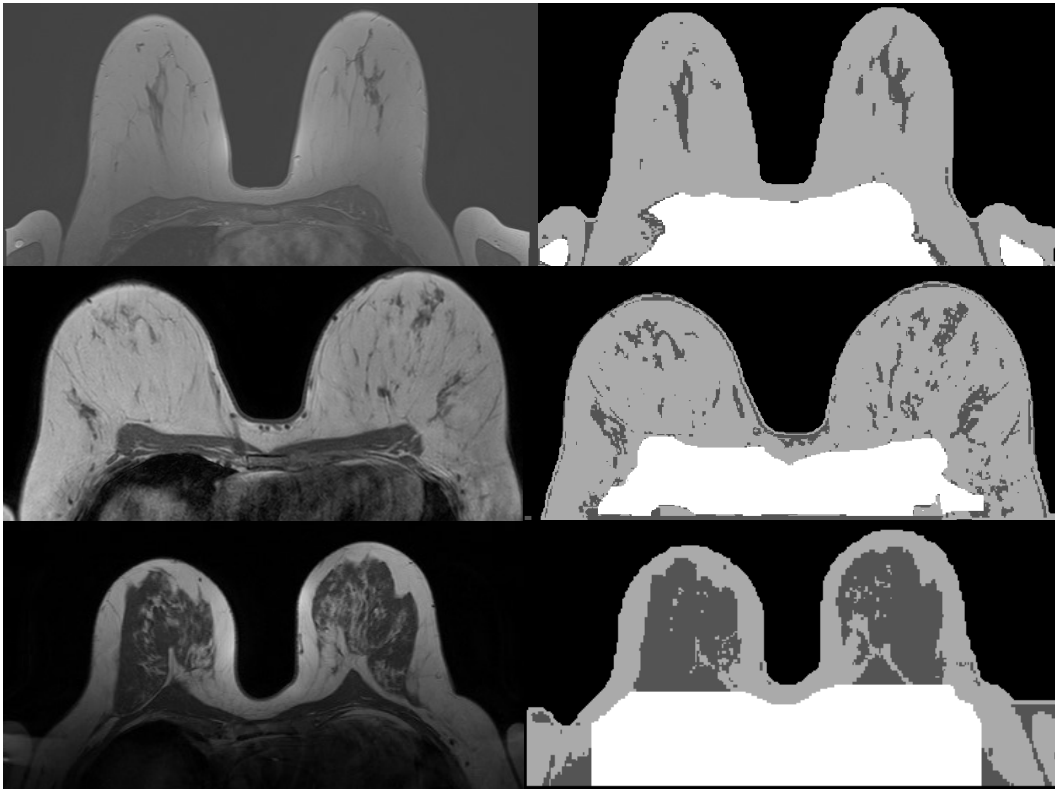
Three examples of clinical datasets of T1-weighted MRI series that has been segmented using the proposed methods. Original images (first column). Segmented images (second column).
